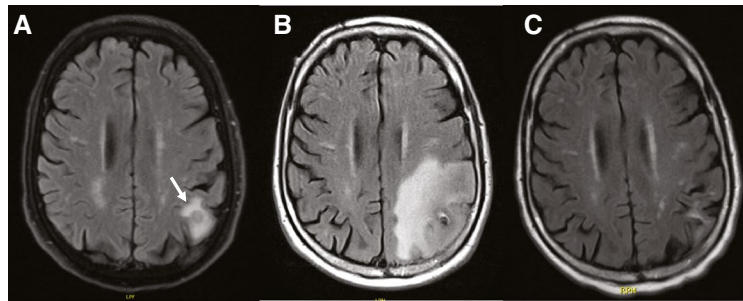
Radiation necrosis. (A) Axial T2/fluid-attenuated inversion recovery-weighted sequences on magnetic resonance imaging reveal a left parietal lesion with surrounding edema (arrow), which was treated with stereotactic radiosurgery. (B) Seven months later, the patient presented with a seizure, and imaging reveals significantly increased edema surrounding the treated left parietal lesion with internal blood products suggestive of radiation necrosis. (C) Repeat magnetic resonance imaging 6 months later demonstrates interval resolution of edema.
